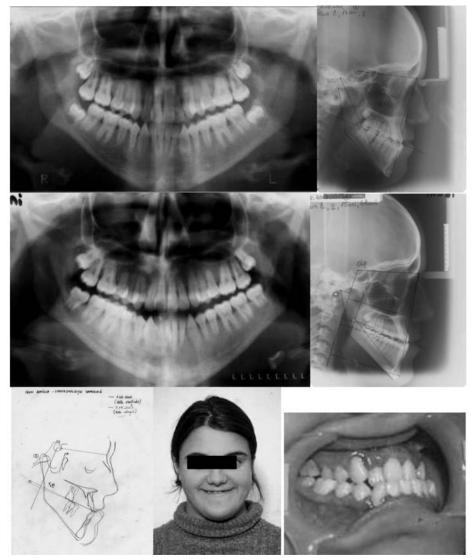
Patient P. D., female, orthopantomograms and lateral skull radiographs at the ages of 14 years, 15 years and 6 months; tracings superimposition, facial and dental aspects
